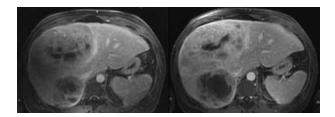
MRI before (left) and after (right) intrahepatic chemo-embolization therapy. No significant change in volume nor necrosis was observed.
